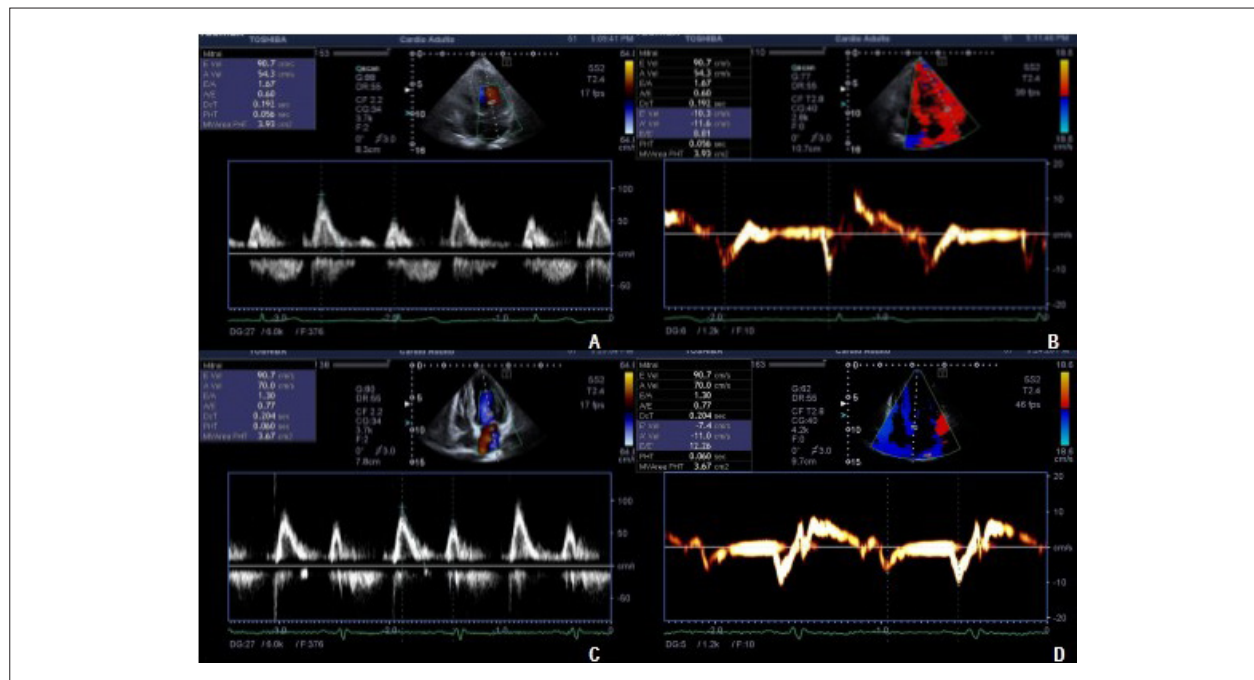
A and B: Pulsed Doppler images showing transmitral flow and septal tissue Doppler showing a normal diastolic pattern. C and D: Tissue Doppler images showing a reduced e' wave (7.4 cm/s), compatible with moderate diastolic dysfunction (pseudonormal pattern).
